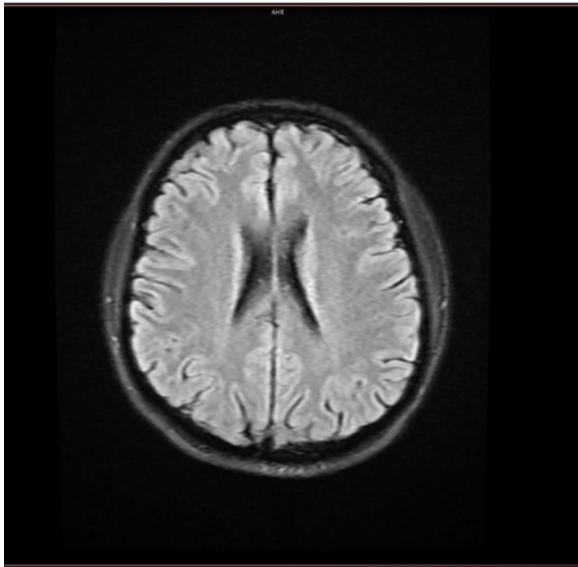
MRI scan of the case was normal.
